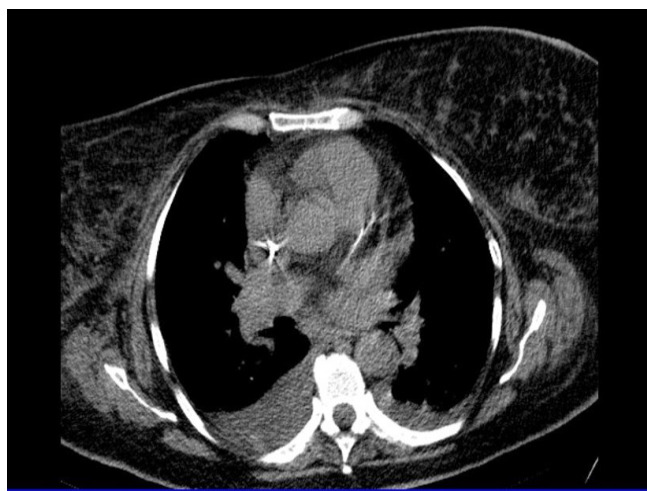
The CT scan of the chest (multiple foci of opacity disseminated in both lung fields, bilateral pleural effusion)
